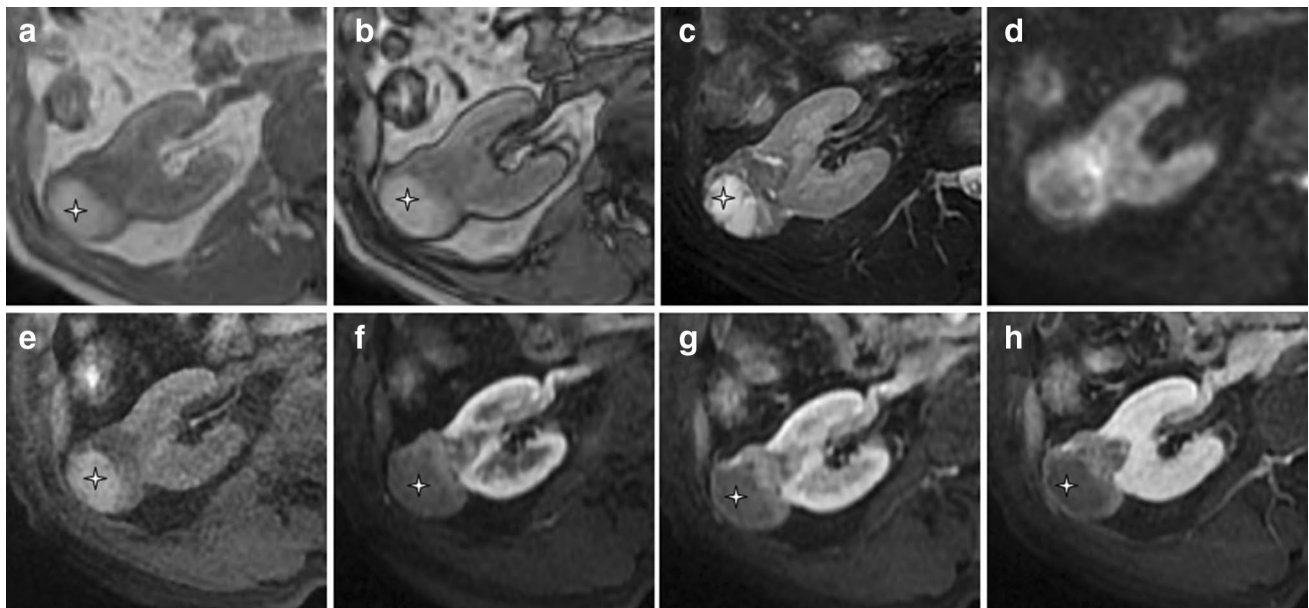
A 45-year-old asymptomatic man with right renal EAML. a On the in phase image the lesion shows heterogeneous hyperintensity with exophytic growth. b On the out-of-phase image the signal intensity of the lesion does not change in comparison with the in phase image. c On the T2-weighted image the lesion shows heterogeneous hypointensity and hyperintensity. d On DWI the lesion shows
